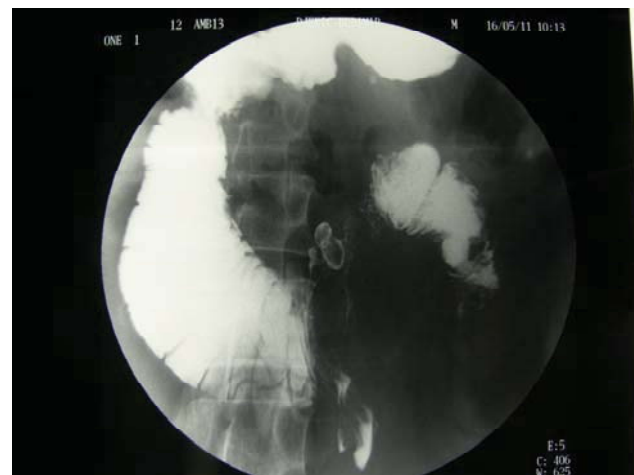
X-ray of gastroduodenum – almost a complete obstruction of the duodenal lumen with proximal duodenal dilatation
